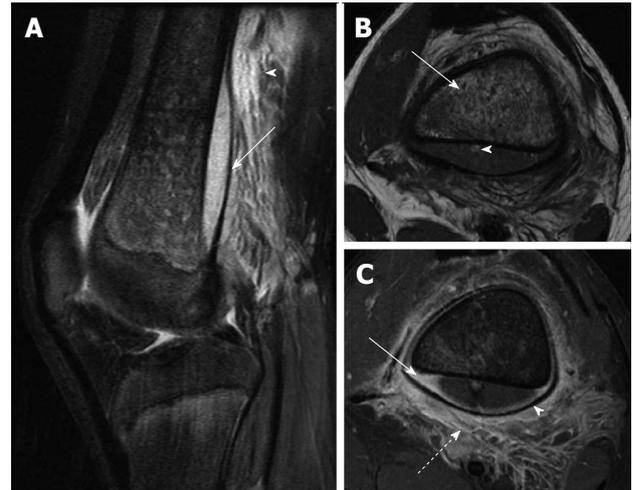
Osteomyelitis with subperiosteal abscess. A: Sagittal T2-weighted image with fat suppression shows a large subperiosteal abscess (solid arrow) with adjacent soft tissue edema (arrowhead); B: Axial T1-weighted image shows heterogeneous T1 hypointense marrow signal (solid arrow). Note small T1 hyperintense focus in the posterior subperiosteal fluid collection (arrowhead) indicative of a fat globule; C: Axial T1-weighted post-contrast image demonstrates peripheral enhancement of the subperiosteal abscess (solid arrow), significant periosteal elevation (arrowhead) and adjacent soft tissue inflammation (dashed arrow).
